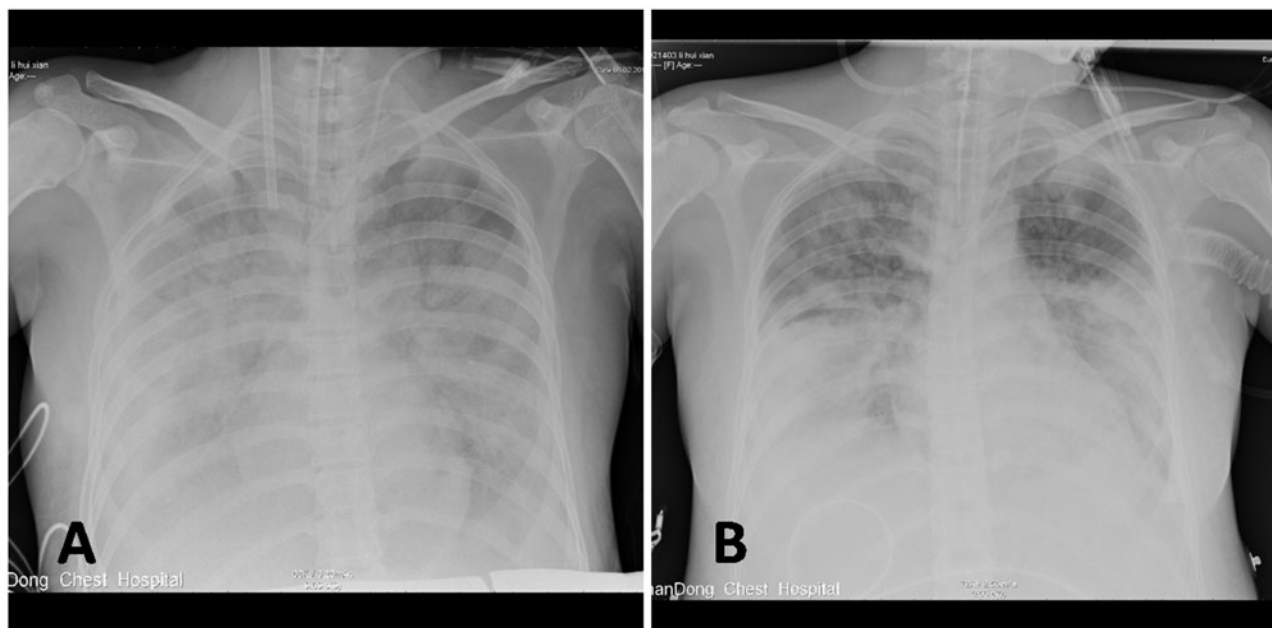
Chest X-ray was performed before labour induction with ECMO (A) and after labour induction weaned from ECMO (B), respectively. In figure (A), the outflow cannula was visible in the right jugular vein. Extensive bilateral infiltrates were severe in figure (A) and absorbed in both upper lobes in figure (B).
